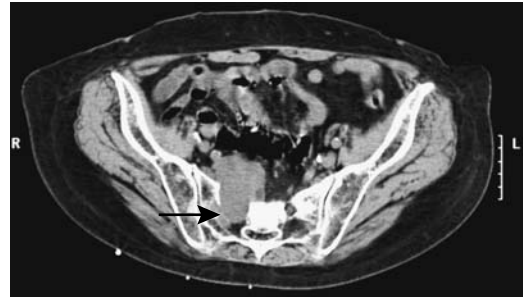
Schwannoma exiting sacral foramen. Noncontrast CT identifies a soft tissue tumor widening a sacral foramen on the right (arrow). (Courtesy of Patrick Fultz, M.D., University of Rochester.)
